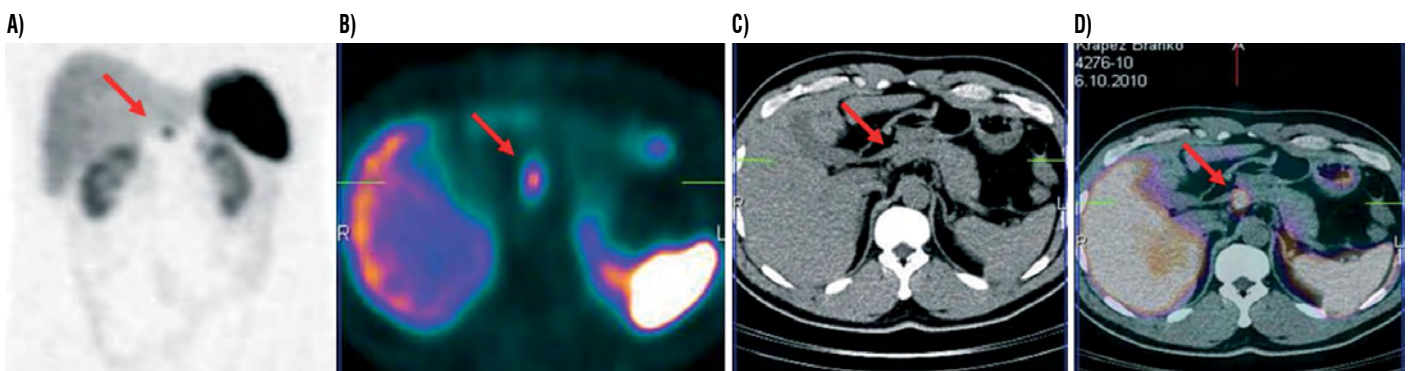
^{99m}Tc labelled somatostatin analogue octreotide: Increased tracer uptake in the upper abdomen (arrow), (A) MIT (Maximal intensity image), (B) SPECT, (C) CT, (D) Fused image: lesion is located in the head of pancreas representing primary solitary neuroendocrine tumour - insulinoma
